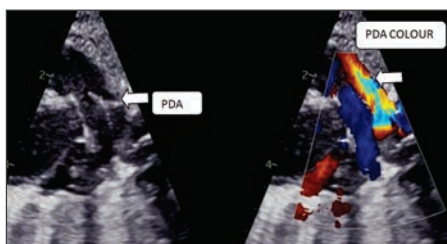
echo showing tubular PDA with 2D and colour doppler
